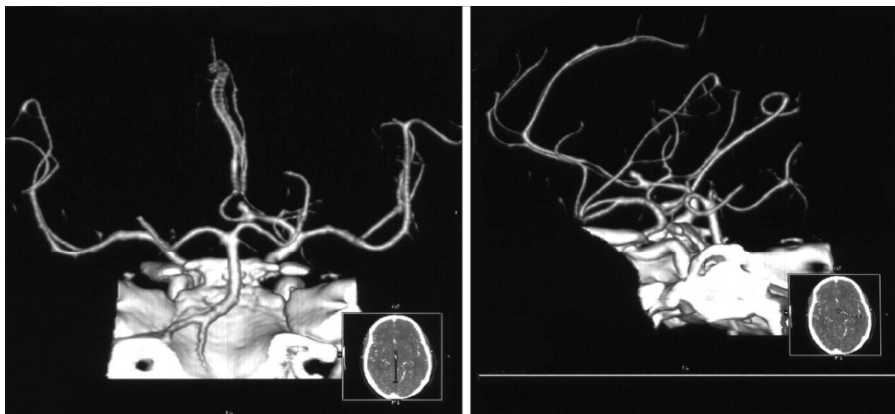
Computed tomography angiography—anterior communicating artery aneurysm
